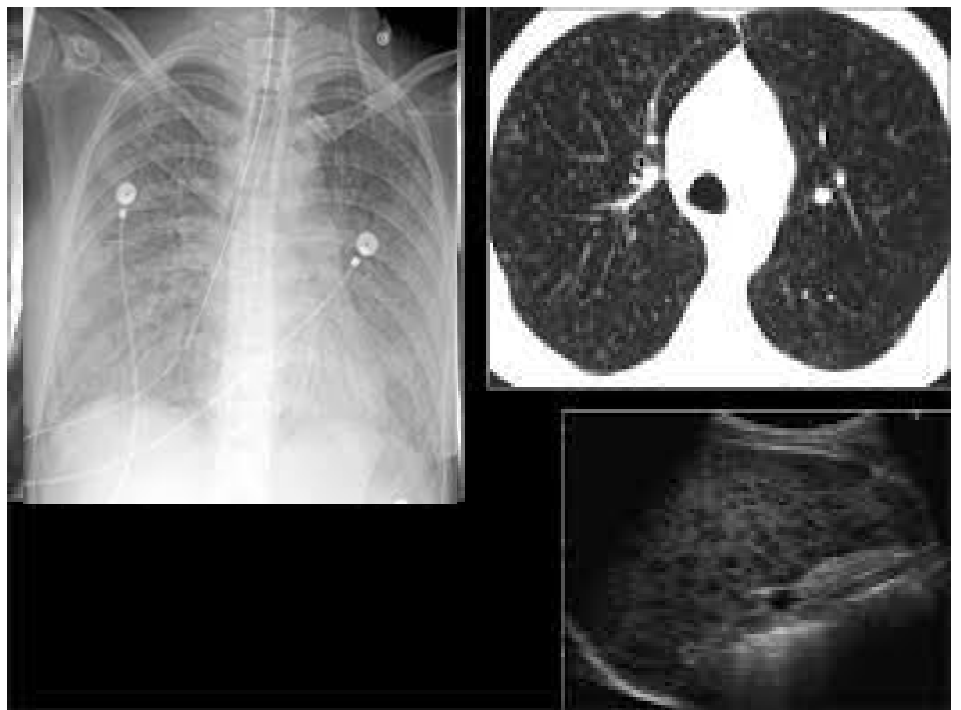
Chest x-ray upon admission. M: pulmonary pattern. Arrow shows curvature at the right upper lobe.
